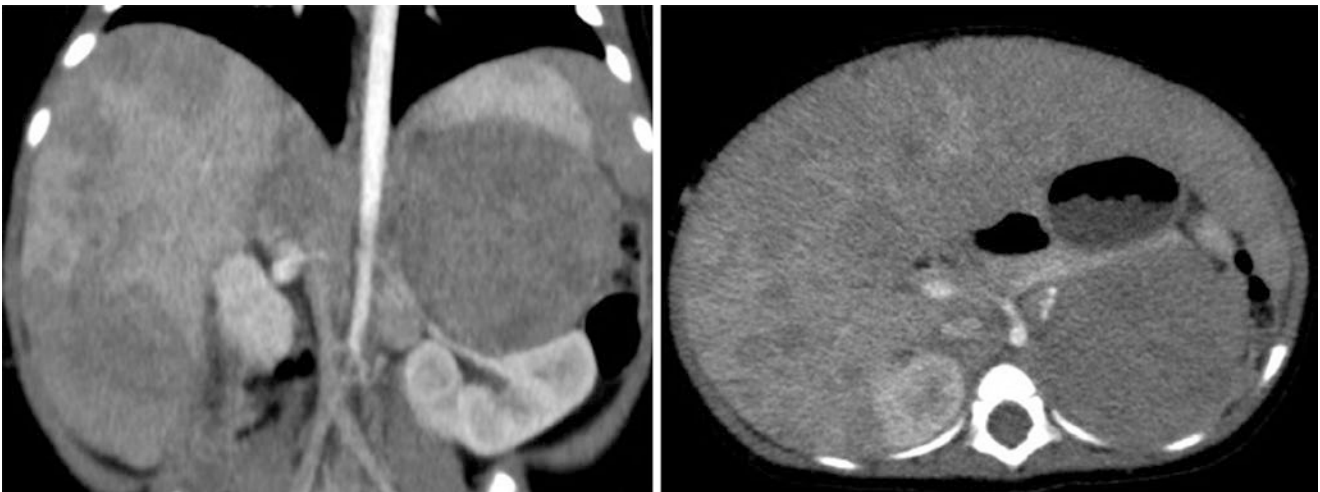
Girl, aged 2 months, presenting a left adrenal neuroblastoma with liver metastasis on CT scan
